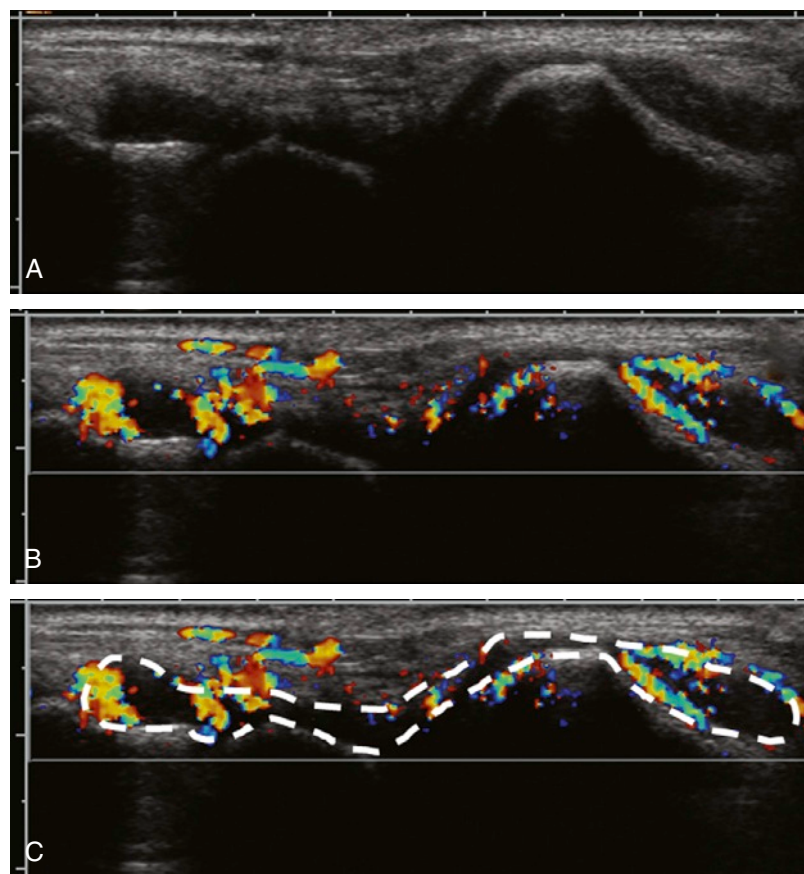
DETERMINATION OF THE COLOR FRACTION. The hypertrophic synovium is identified (A), and the color Doppler image with maximum color activity is selected for analysis (B). The synovium inside the color box is traced, thereby outlining (dashed line) the region of interest (C). The amount of color pixels is expressed relative to the total amount of pixels in the marked region of interest; this is the color fraction.
